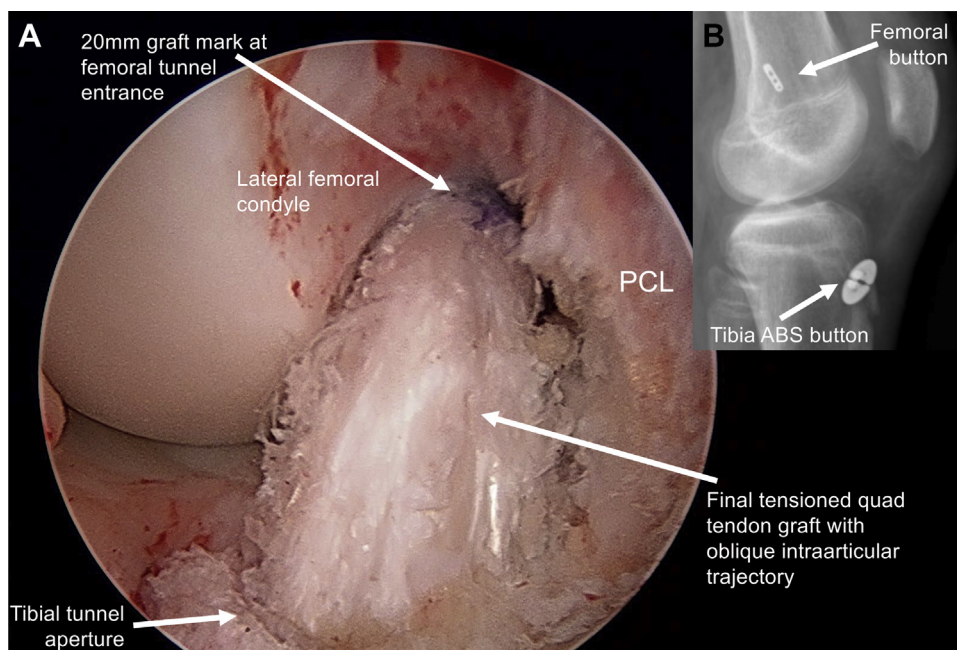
Final arthroscopic (A) and lateral radiographic (B) views of a right knee after anterior cruciate ligament reconstruction with quadriceps (quad) tendon autograft using the hybrid transtibial technique. (A) Viewing from anteromedial portal (the right part of the image is medial), the quadriceps tendon graft replicates the native oblique anterior cruciate ligament trajectory and is well tensioned after knee cycling and sequential tightening of the femoral and tibial buttons. (B) A lateral radiograph shows proper femoral and tibial button fixation of the graft, as well as graft tunnel trajectories. (PCL, posterior cruciate ligament.)
